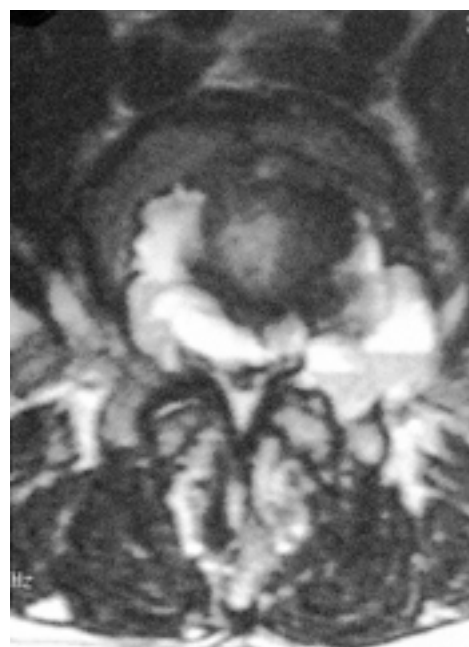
A 47-year-old man with lumbar aneurysmal bone cyst. Axial T2-weighted image shows an expansile vertebral body mass with heterogeneous high signal, compressing the spinal cord. The mass has multiseptated cysts with fluid - fluid levels.
